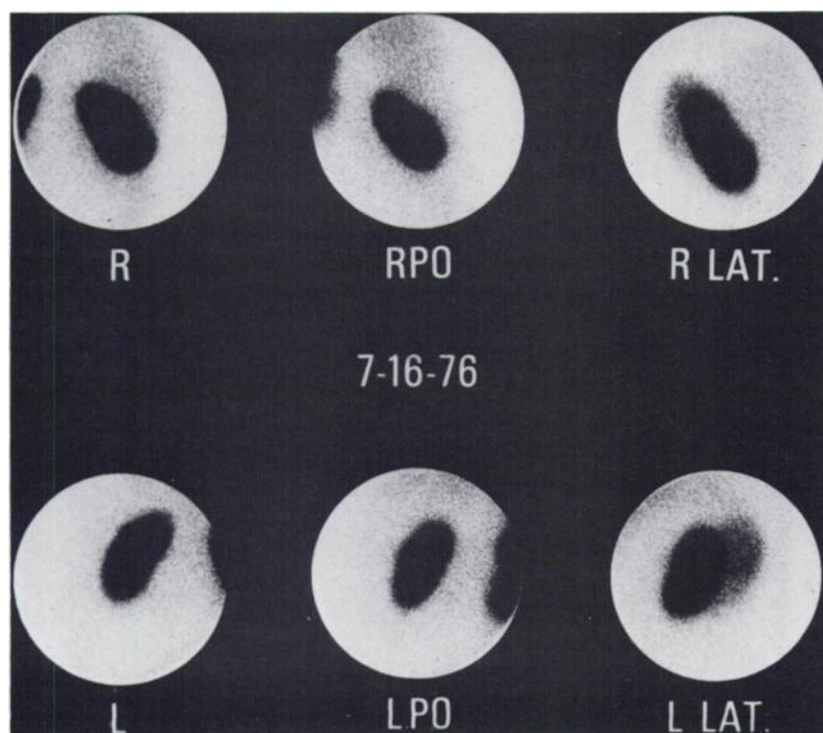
Normal gluceptate scintigram 4 hr after injection. Note minimal liver uptake.
